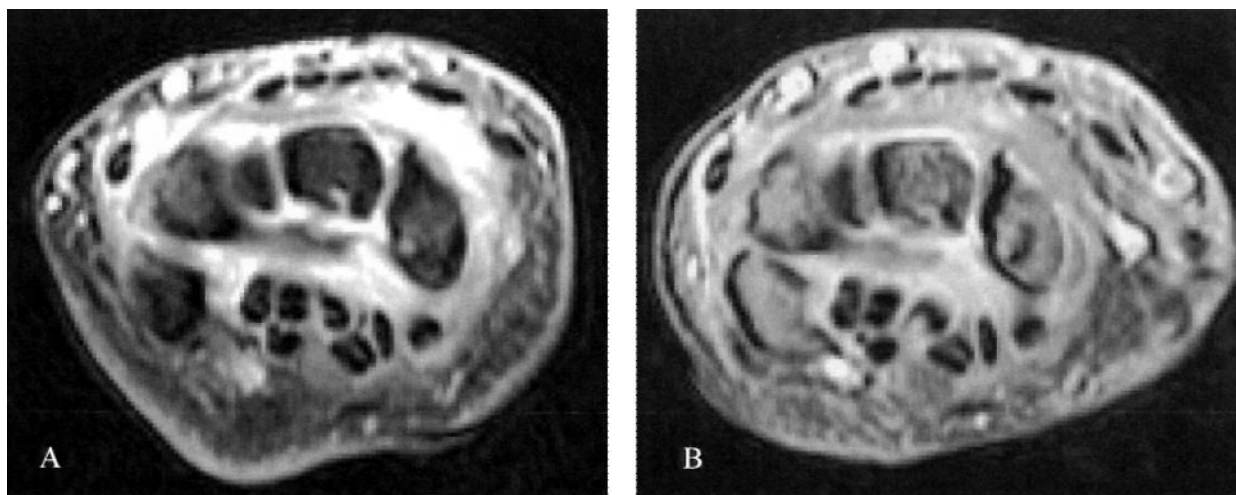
Synovial enhancement with Gd-DTPA. A. Axial 3D gradient echo image of a wrist following iv Gd-DTPA shows extensive enhancing synovitis and distention of the synovial cavity. B. Repeat MRI with Gd-DTPA after 3 months of DMARD therapy shows marked reduction in the amount of enhancing tissue but similar distention of the synovial cavity (note the dorsally displaced extensor tendons).
